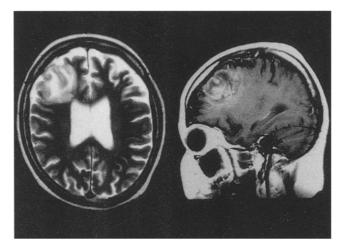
Axial (left) and sagittal (right) postcontrast T2-weighted images demonstrate striking enhancement with high signal intensity of an inhomogeneous mass in the right frontal lobe.
